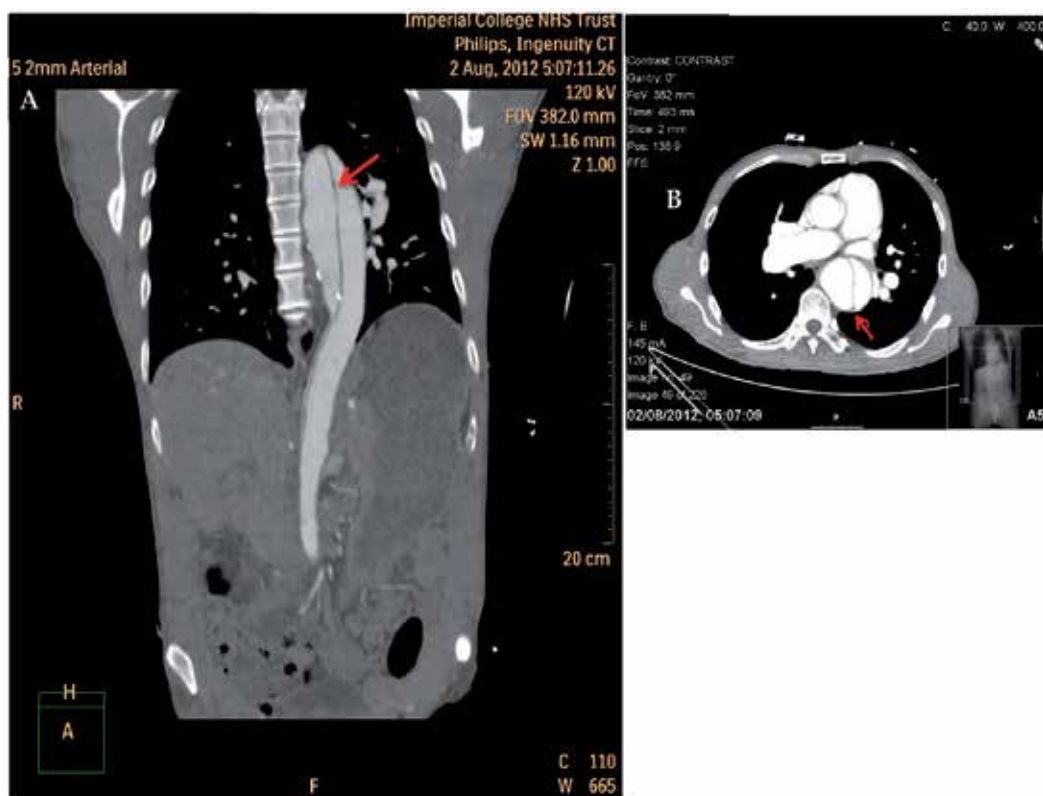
Aortic dissection CT angiogram of type B aortic dissection in A) coronal and B) axial planes. Arrow indicates dissection flap caused by separation of the layers of the aortic wall, with blood within the layers forming a true and false lumen
